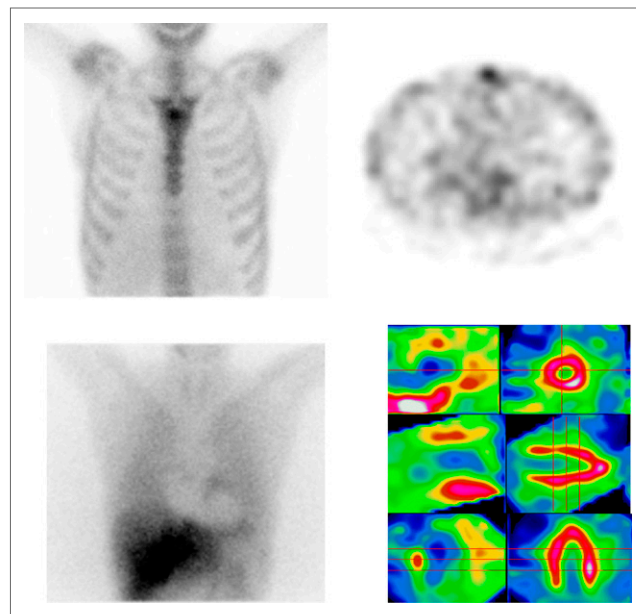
$^{99\text{m}}\text{Tc}$ -diphosphonate (top) and ^{123}I -MIBG imaging (bottom) in a 39-year-old woman with genetically proven transthyretin familial amyloid polyneuropathy symptomatic for cardiac involvement (left ventricular ejection fraction = 73%). Top: SPECT showed no diphosphonate uptake in the cardiac area. Bottom: ^{123}I -MIBG scintigraphy (left) and simultaneous dual-isotope (right; ^{123}I -MIBG and $^{99\text{m}}\text{Tc}$ -MIBI) cardiac CZT camera imaging showed diffuse and heterogeneous denervation.
